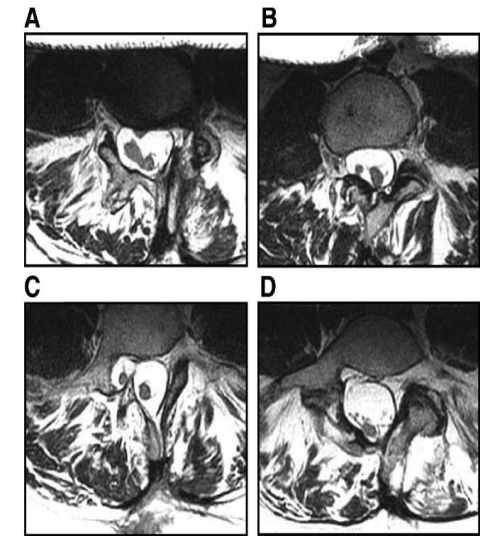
Axial MRI slices of the lumbar spine. A, Lumbar segment rostral to diastematomyelia, (B, C) lumbar segments at diastematomyelia, and (D) lumbar segment and cauda equina caudal to diastematomyelia.
